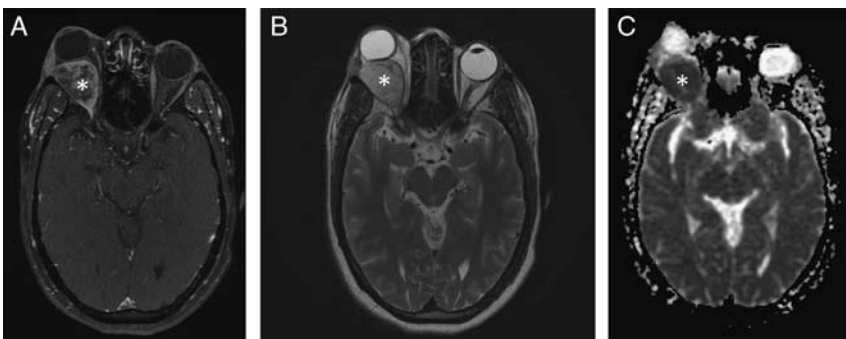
43-year-old man presented with subacute right eye proptosis and underwent resection of a right lacrimal gland mass, which was demonstrated to be adenoid cystic carcinoma at pathology. Axial T1-weighted postcontrast fat-saturated MRI demonstrates an enhancing right retrobulbar orbital mass involving the extraconal and intraconal spaces and extending to the orbital apex (A, white asterisk). Axial T2-weighted MRI demonstrates the mass to be heterogeneously T2 hyperintense (B, white asterisk). Axial apparent diffusion coefficient MRI shows the mass is hypointense consistent with restricted diffusion (C, white asterisk). MRI indicates magnetic resonance imaging.
